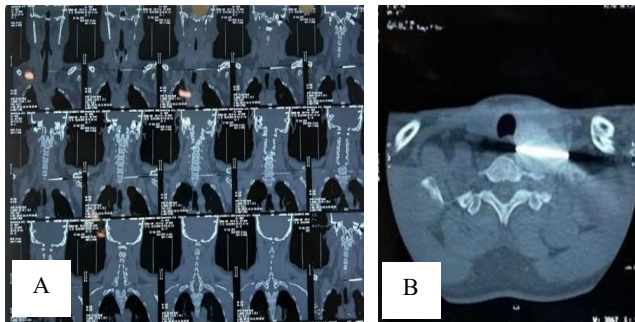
(A and B): CT neck.
